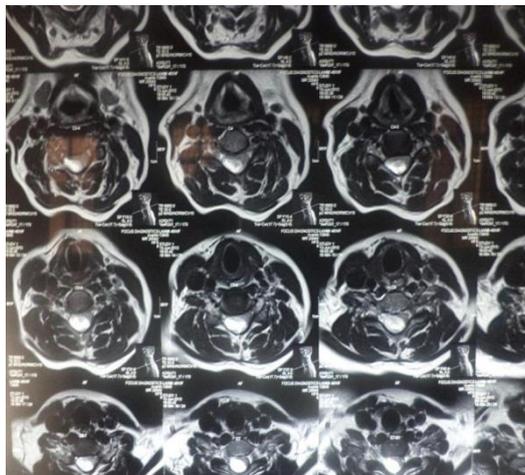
MRI spine in Schwannoma
